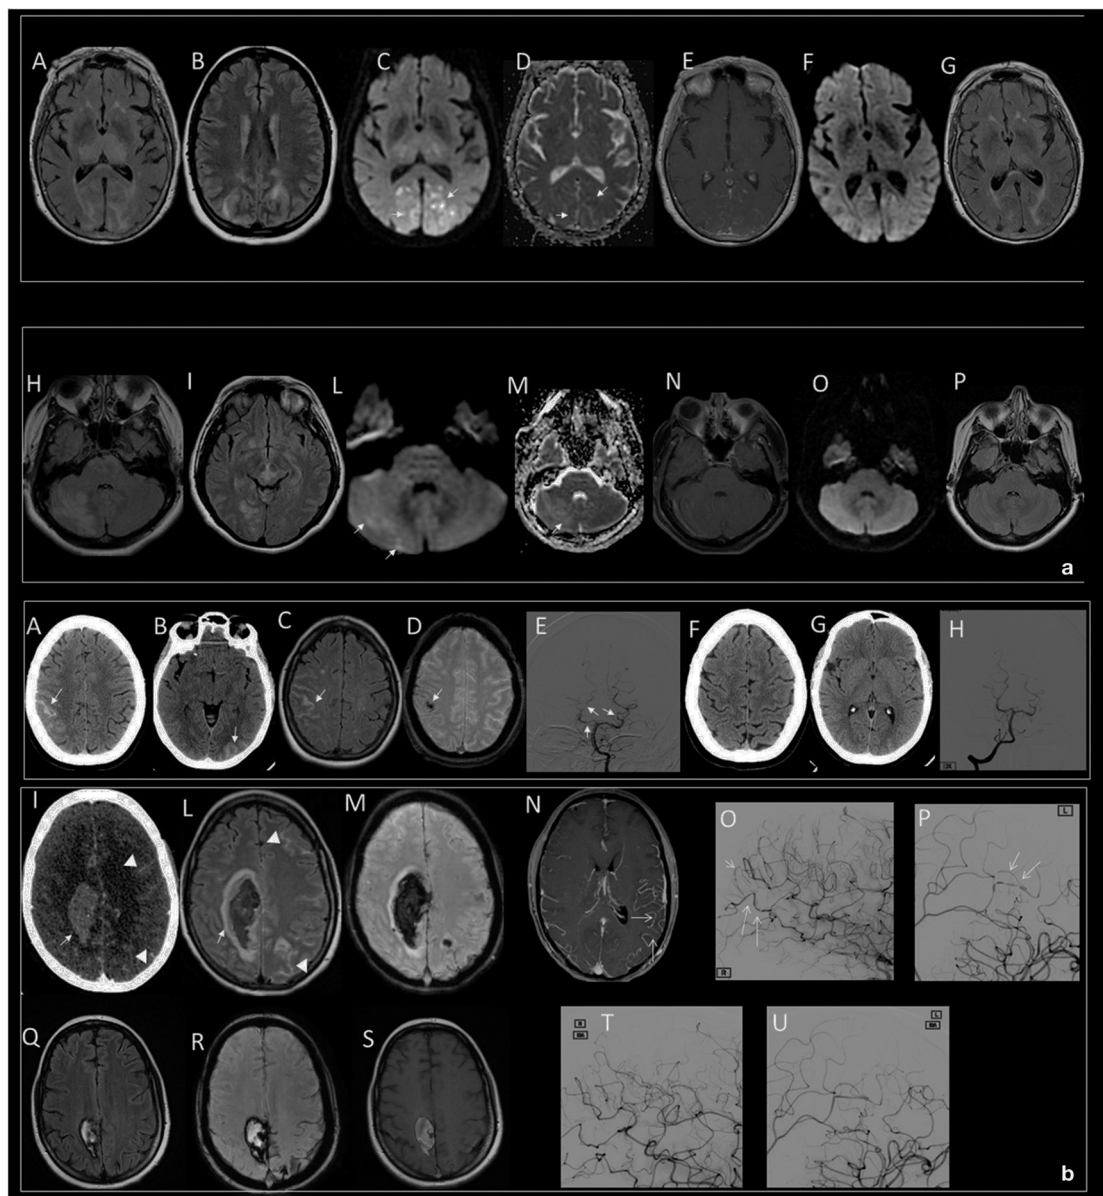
(a) Typical dominant parietal–occipital pattern in a patient with PRES at the onset (A–E) and after 15 days (F,G). (A,B,G) FLAIR MR images; (C,F) DWI MR images; (D) ADC map; (E) T1 C+ MR image. Edema involves the parietal and occipital cortex and white matter (A,B); small, patchy, or punctate hyperintensity in DWI (white arrows in C) corresponding to hypointensity in ADC map (white arrows in D) characterize the cytotoxic edema within diffuse vasogenic edema; gyral or leptomeningeal enhancement is shown in occipital regions (E). Note resolution of the lesions 15 days after the onset (F,G). Atypical involvement of the brainstem associated to occipital pattern in a patient with PRES at the onset (H–N) and after 18 days (O,P). (H,I,P) FLAIR MR images; (L,O) DWI MR image; (M) ADC map; (N) T1 C+ MR image. Edema involves the right cerebellum, brainstem, and occipital cortex and white matter (H,I); iso-intensity with punctate foci of hyperintensity in DWI (white arrows in L) and hyperintense signal in ADC characterizes the vasogenic edema (white arrow in M), no enhancement is shown (N). Note resolution of the lesions 18 days after the onset (O,P). (b) Intracranial subarachnoid hemorrhage in a patient with RCVS at the onset (A–E) and after 2 months (F–H). Axial CT (A,B) shows hyperdense subarachnoid hemorrhage in the right frontal (white arrow in A) and left occipital lobes (white arrow in B); axial FLAIR MR (C) confirms subarachnoid hemorrhage as hyperintense sulci (white arrow in C); SWI MR images (D) show a component of subarachnoid hemorrhage as hypointense focus within a frontal sulcus (white arrow in D); catheter angiography of vertebro-basilar arteries demonstrate vessel irregularities with focal vasoconstriction (white arrow in E). Note resolution of SAH (F,G) and vessel irregularities (H) after 2 months. Intraparenchymal hematoma and subarachnoid hemorrhage in a patient with post-partum RCVS at the onset (I–P) and after 3 months (Q–U). Axial CT (I) shows hyperdense parenchymal hematoma in the right frontal lobe (white arrow in I) and subarachnoid hemorrhage in the left frontal lobe (white head of arrows in I); FLAIR MR (L) shows vasogenic edema marginally at the right parenchymal hematoma (white arrow in L) and left subarachnoid hemorrhage as hyperintense sulci (white head of arrows in L); SWI MR image (M) shows the hypointense signal of the parenchymal and subarachnoid hemorrhage due to acute phase of hemorrhage; contrast-enhanced MRA (CE-MRA) (N) images show vasoconstriction of some distal branches of middle cerebral arteries (with arrows in N); catheter angiography of internal carotids confirms diffuse irregularities with multifocal narrowings throughout the cerebral vasculature with a “string-of-beads” appearance (white arrows in O,P). Note reduction of ICH and SAH (Q–S) and disappearance of multifocal narrowings of distal branches of middle cerebral arteries after 3 months (T,U).
